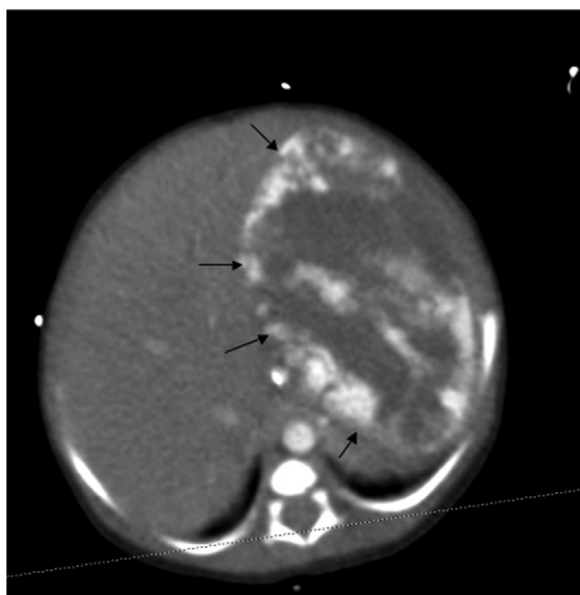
Contrast-enhanced abdominal computed tomography scan of a 4-day-old infant with a large focal hemangioma of the left hepatic lobe. Note the central area of necrosis.
